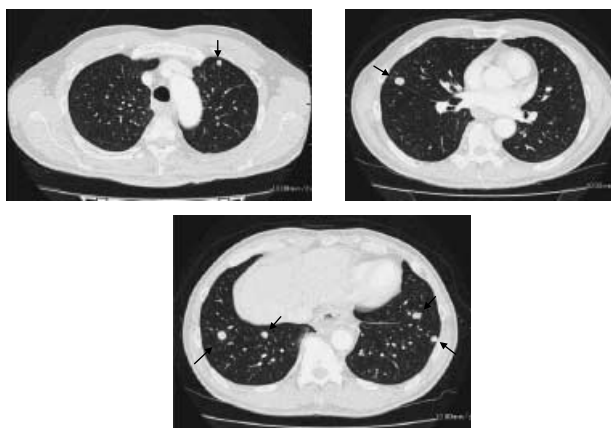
CT finding before chemotherapy demonstrated multiple lung metastases in the bilateral lungs (arrows)
